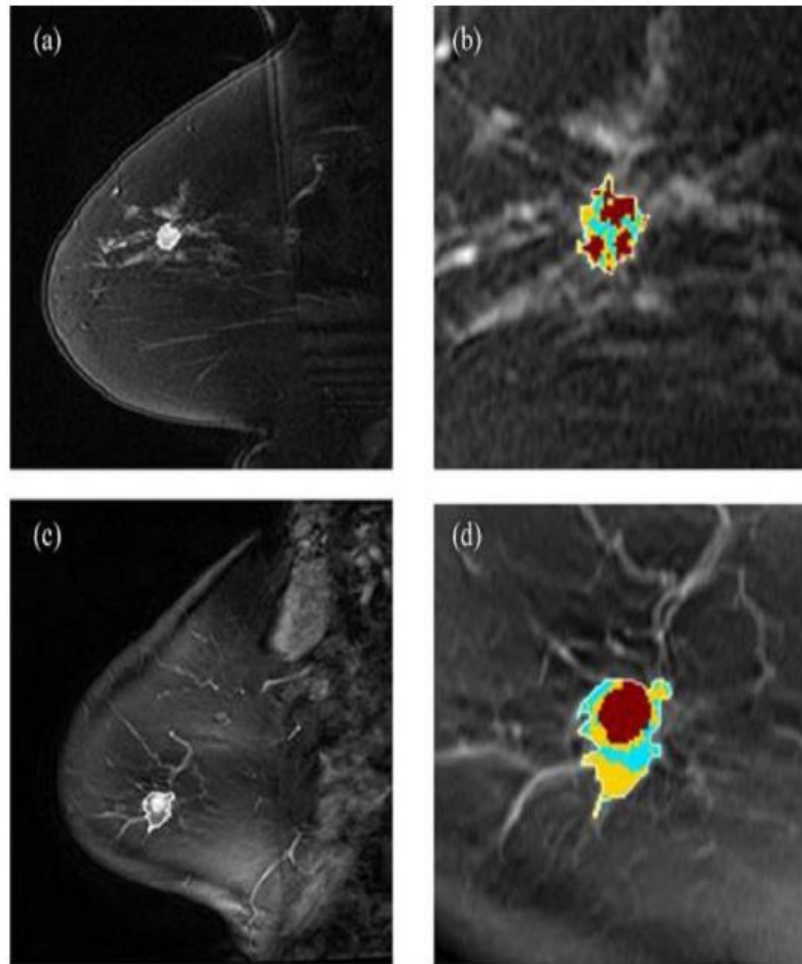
Fig First post-contrast breast DCE-MR images (first column) and corresponding PK heterogeneity partitioning (second column; teal, gold, and darkred partitions represent low, medium, and high maximum first contrast uptake)for (a), (b) low recurrence risk and (c), (d) high recurrence risk tumor examples.
